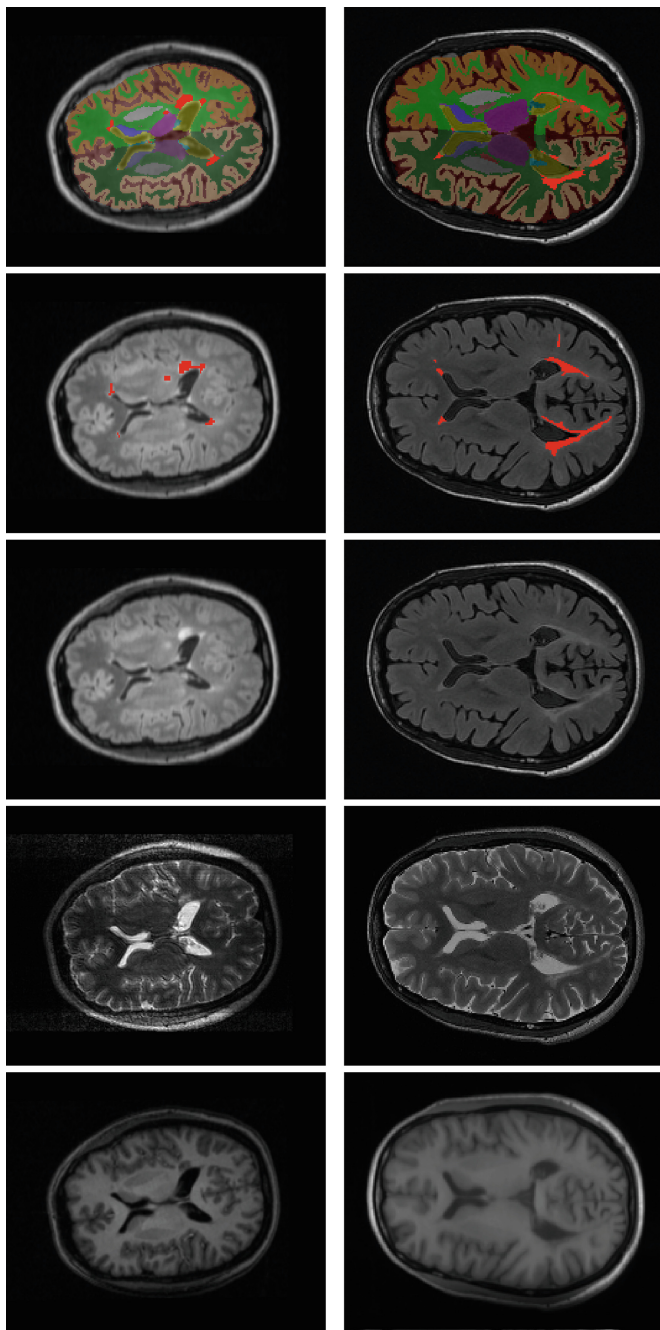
Example segmentations from two subjects: CHB04 (first row) and CHB08 (second row). From left to right: T1-weighted scan, T2-weighted scan, FLAIR scan, manual segmentation overlaid on the FLAIR scan, and the full segmentation obtained using the proposed method. Lesions are denoted in red (Color figure online).
